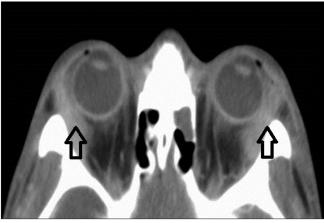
Axial CT image showing bilateral lacrimal gland inflammation (arrows)
